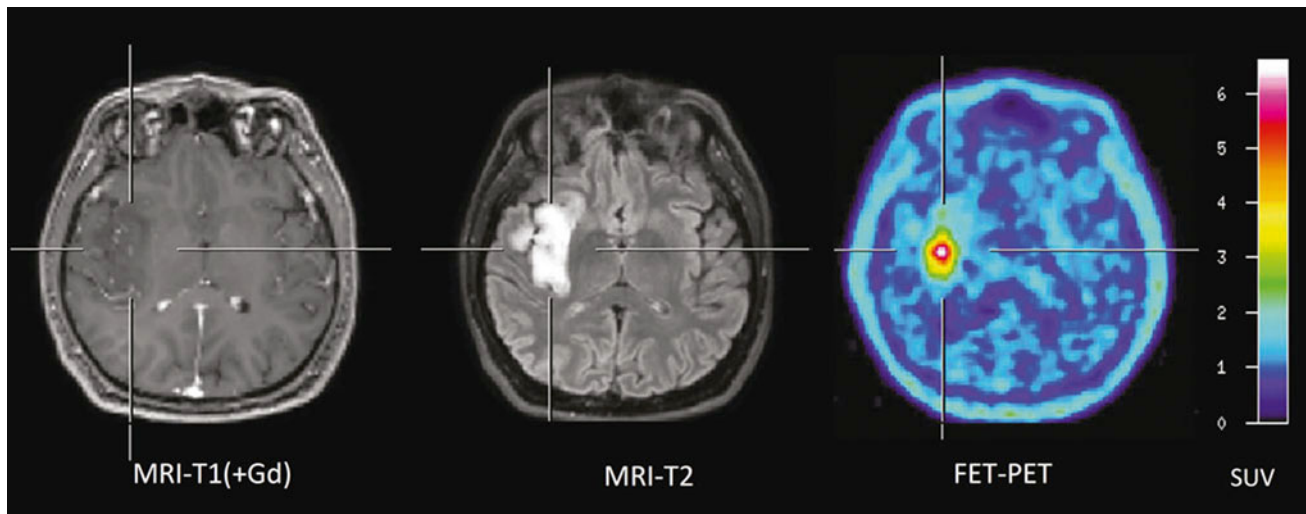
Patient with a diffused astrocytoma of WHO grade II. T1-weighted MRI on the left shows no contrast enhancement and in the T2-weighted MRI (middle) diffused signal abnormalities. FET PET identifies a local maximum in the tumor for biopsy guidance
